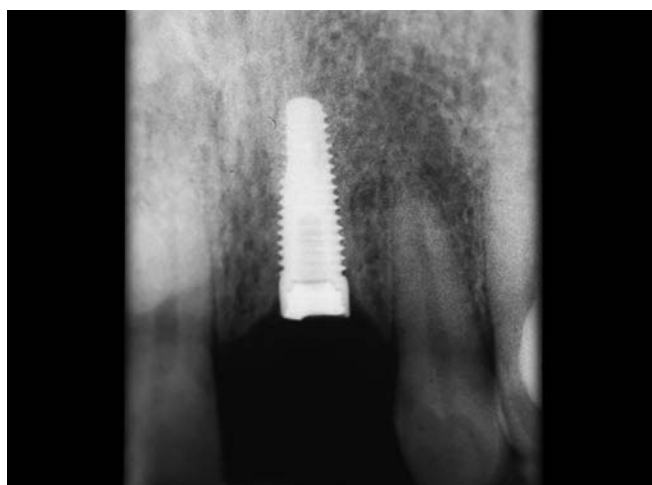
Periapical radiograph displaying bone level implant and fractured zirconium abutment
